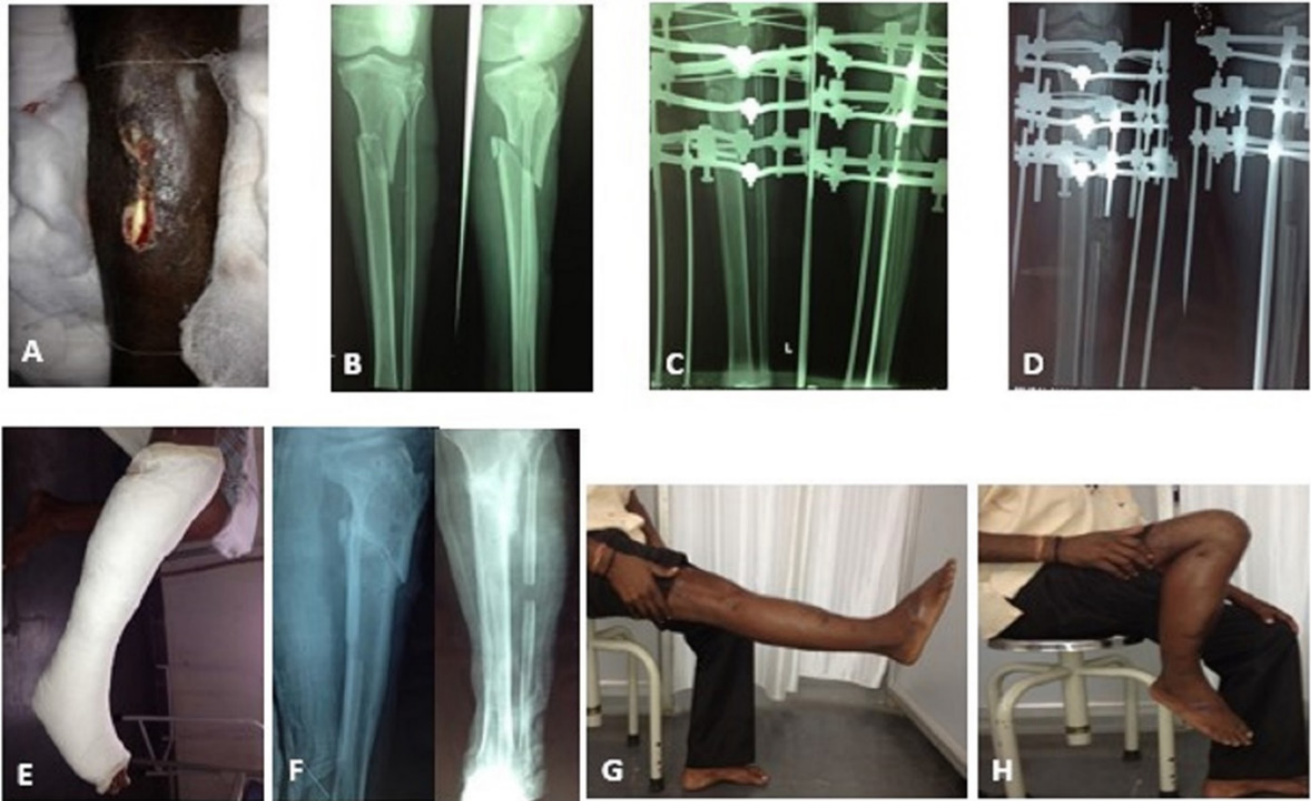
Patient with open fracture of the Tibia (A, B), managed with Ilizarov external fixator (C, D) and PTB (E) showing union of the fracture on X-Ray (F) with good range of movements of knee and ankle (G, H).
